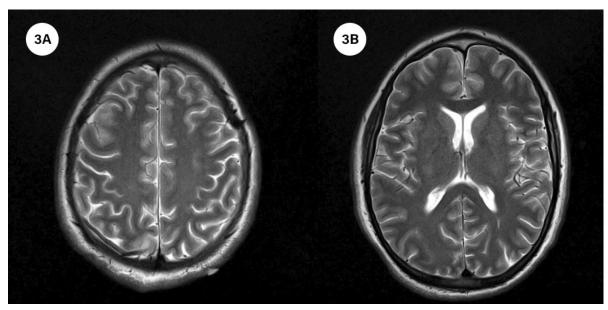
& 3B). T2 Weighted MRI Axial Sections Reveal No Significant Abnormality.
